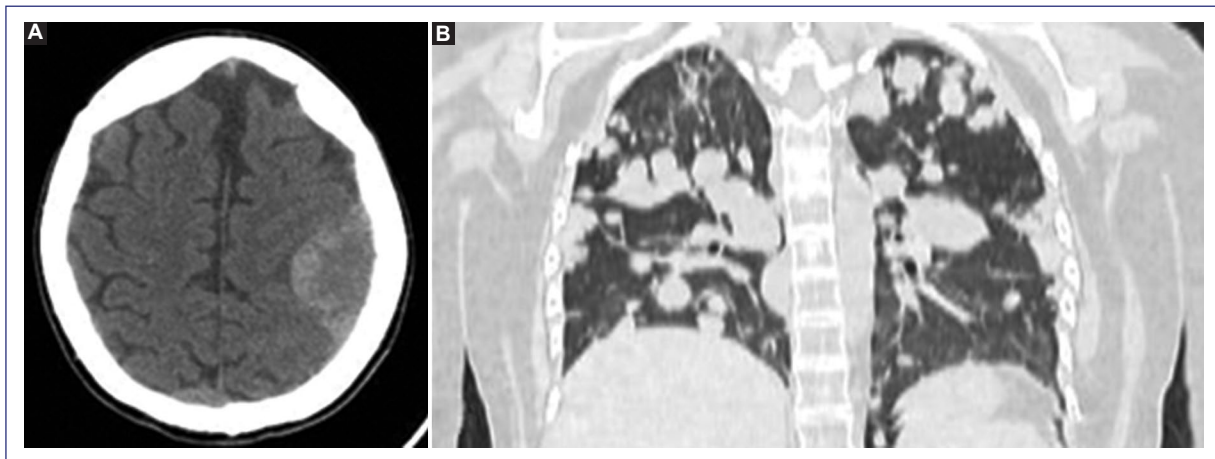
Computed tomography demonstrating. A: subarachnoid and intraparenchymal hemorrhage in the left parietal lobe and. B: progression of the disease in lungs.
